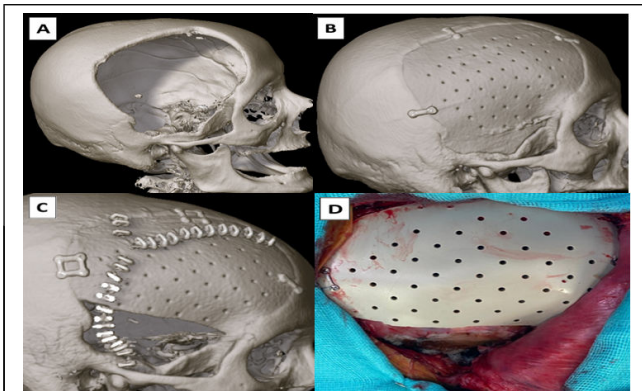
Ruptured right middle cerebral artery aneurysm. (A): Aneurysm Computed Tomography (CT) scan showing the bone defect after decompressive craniectomy; (B): 3D reconstruction CT after custom PEEK cranioplasty placement, showing proper fit; (C and D): 3D reconstruction CT and intraoperative photograph show the end result with the inferior part of the implant removed.
